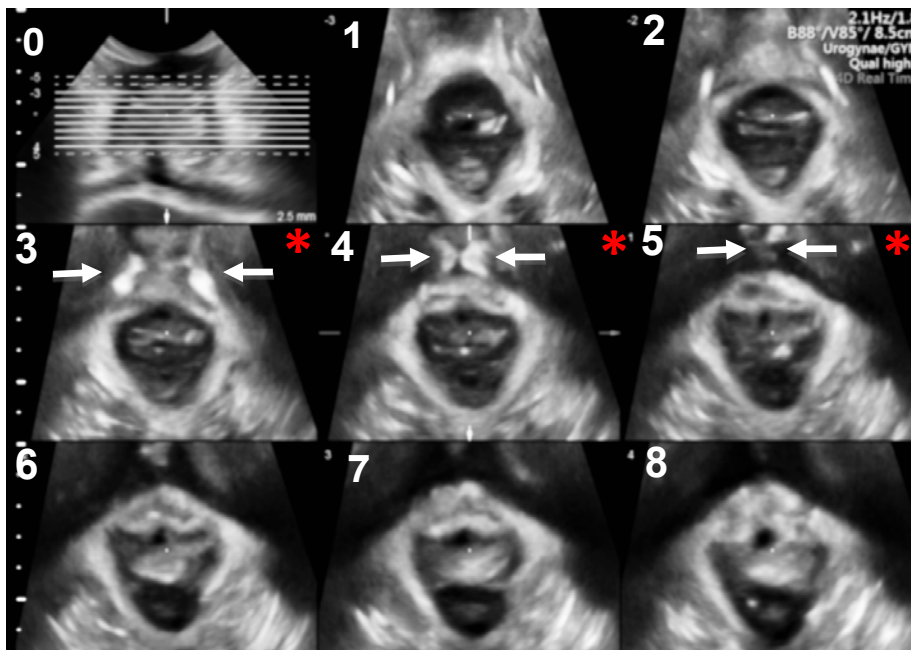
Tomographic ultrasound imaging of an intact puborectalis muscle. Eight axial plane slices are set at 2.5mm interslice intervals. The central slice (Slice 4) is placed at the plane of minimal hiatal dimensions showing ‘closing’ of the symphysis pubis, as identified by arrows. The slice to the left (Slice 3) is set 2.5mm caudad, showing the symphysis pubis open, the one to the right (Slice 5) is 2.5mm cranial, with the pubic rami ‘closed’ or invisible due to acoustic shadowing. The three central slices (Slice 3-5) as represented by the red asterisks are analysed to provide minimal criteria for the diagnosis of levator avulsion.
